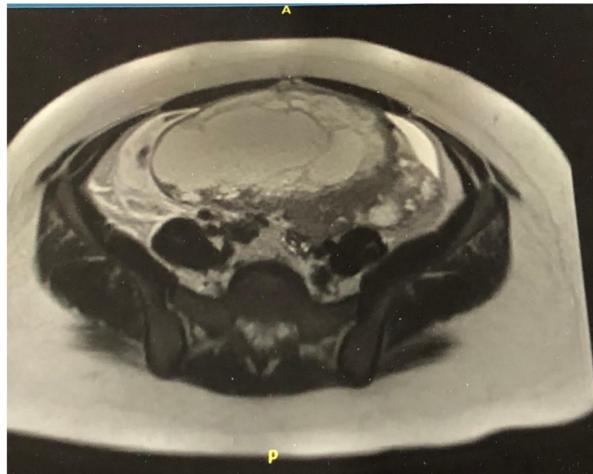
MRI pelvis right adnexal mass 10.0 (AP) x 18.3 (TV) x 19.4 (CC) cm with internal septations, complex cystic changes, and peripheral enhancing nodularity.
